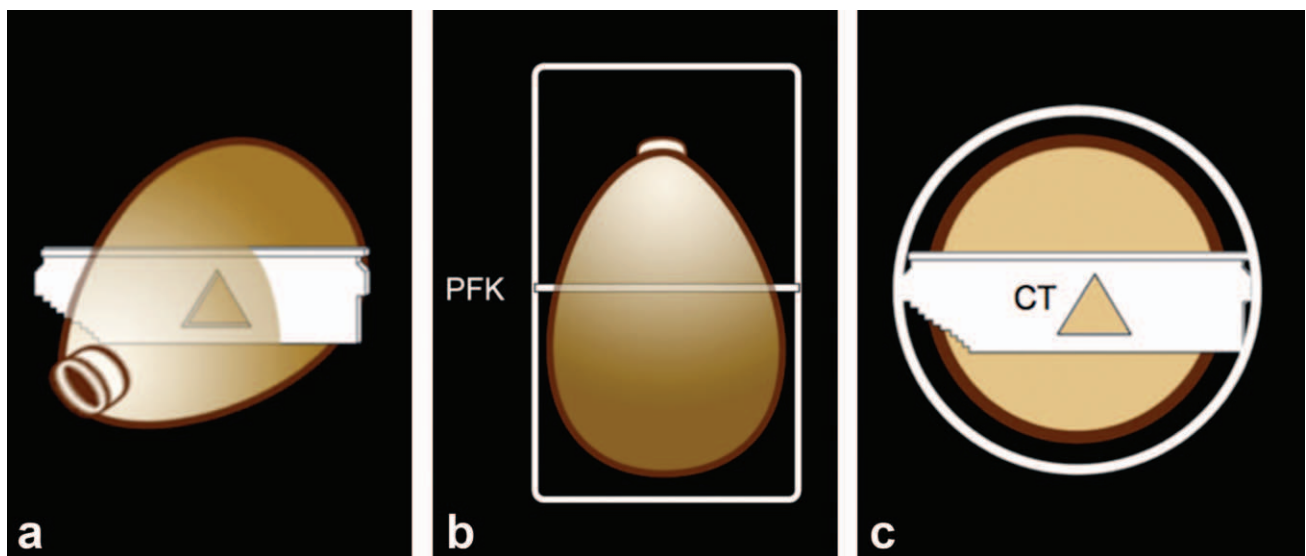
A plane finder key (PFK) is inserted into the prostate (a). The PFK locks into a nonmetallic carrier establishing the plane of imaging, and later the cutting plane (b, coronal view). A central triangle (CT) provides a reference area to improve the alignment of the planes (c, axial view).
